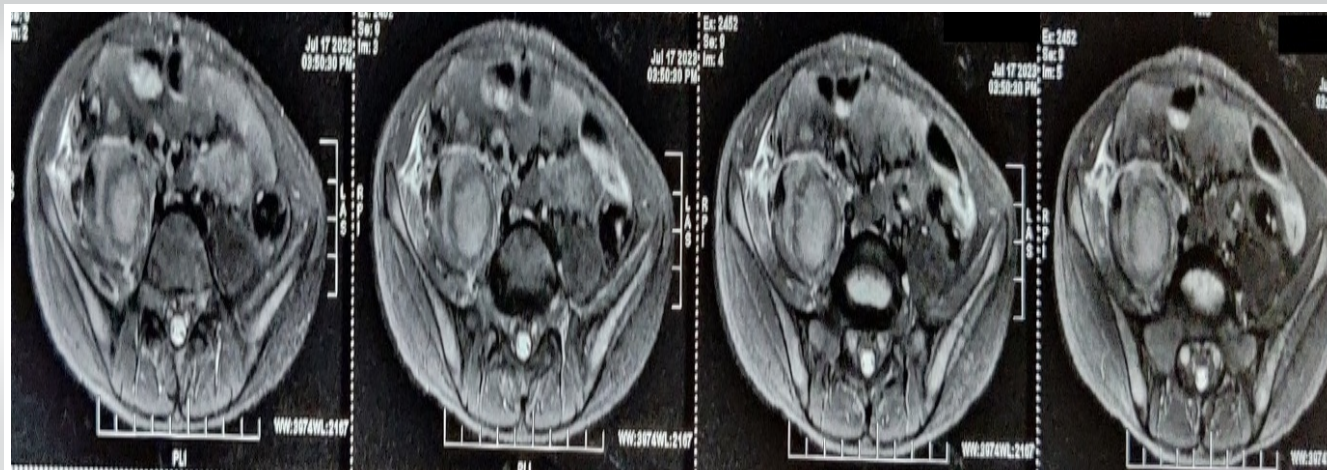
Magnetic resonance imaging (MRI): Axial section of abdomen and pelvis. Plain MRI of the abdomen and pelvis was taken 1 week before surgery. The following is a coronal section showing a large abscess of size 3.3×3 cm in the body of the psoas muscle.
